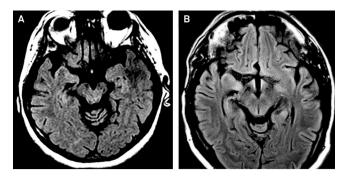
Axial FLAIR image shows increased tegmental signal intensity compared to age matched control.
